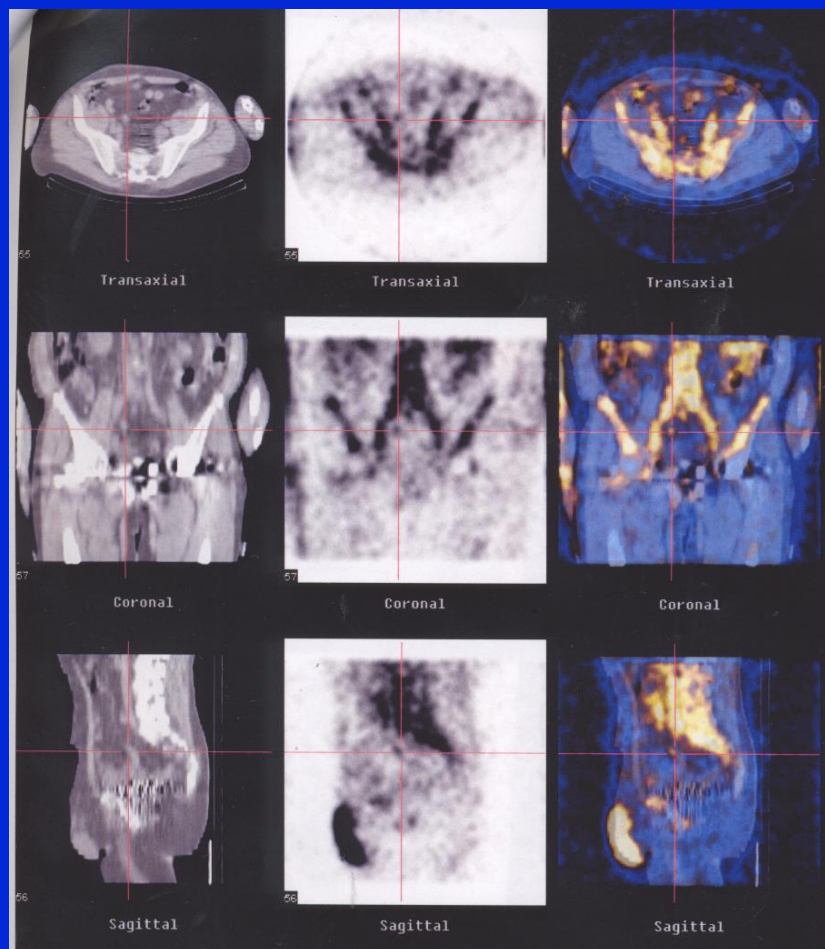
2B. — (A) Planar and (B) SPECT of the pelvis demonstrating increased radioimmunoscintigraphic uptake in area of previous prostatectomy in a patient with rising PSA.
